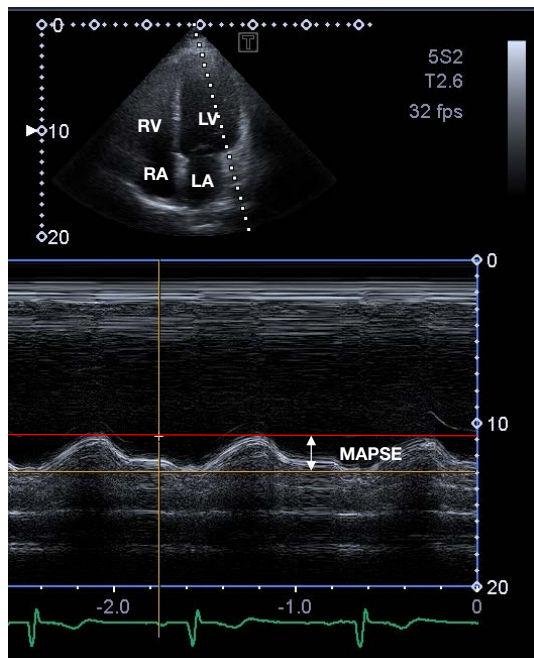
M-mode echocardiography-derived measurement of MAPSE in apical four-chamber long-axis view. LA, left atrium; LV, left ventricle; MAPSE, mitral annular plane systolic excursion; RA, right atrium; RV, right ventricle.
